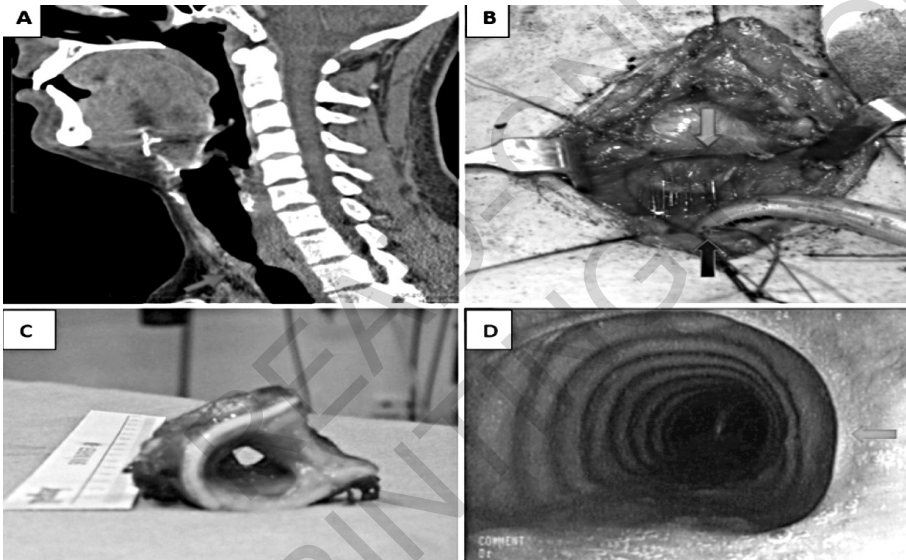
A) Image of the stenotic area on computed tomography; B) Intraoperative view of the end-to-end anastomosis of the trachea after removal of the stenotic area; C) Stenotic fragment removed from the trachea; D) FOB image of the surgical area 1 month postoperatively.
